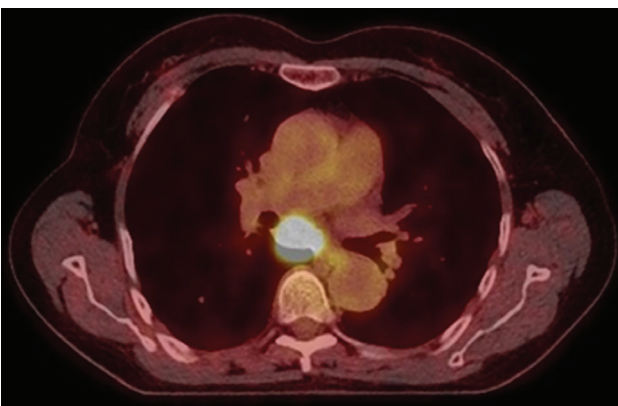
^{18}F FDG PET-CT showing avidity in mediastinal lymph nodes (station 7; standard uptake value 25.1).
